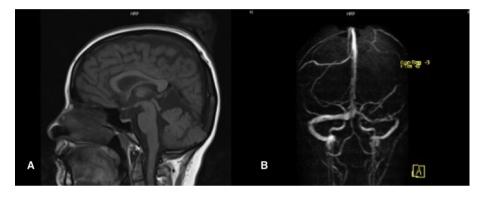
Follow-up sagittal T1-MRI (A) and MRV (B) scan showing complete recanalization of the venous sinuses.
